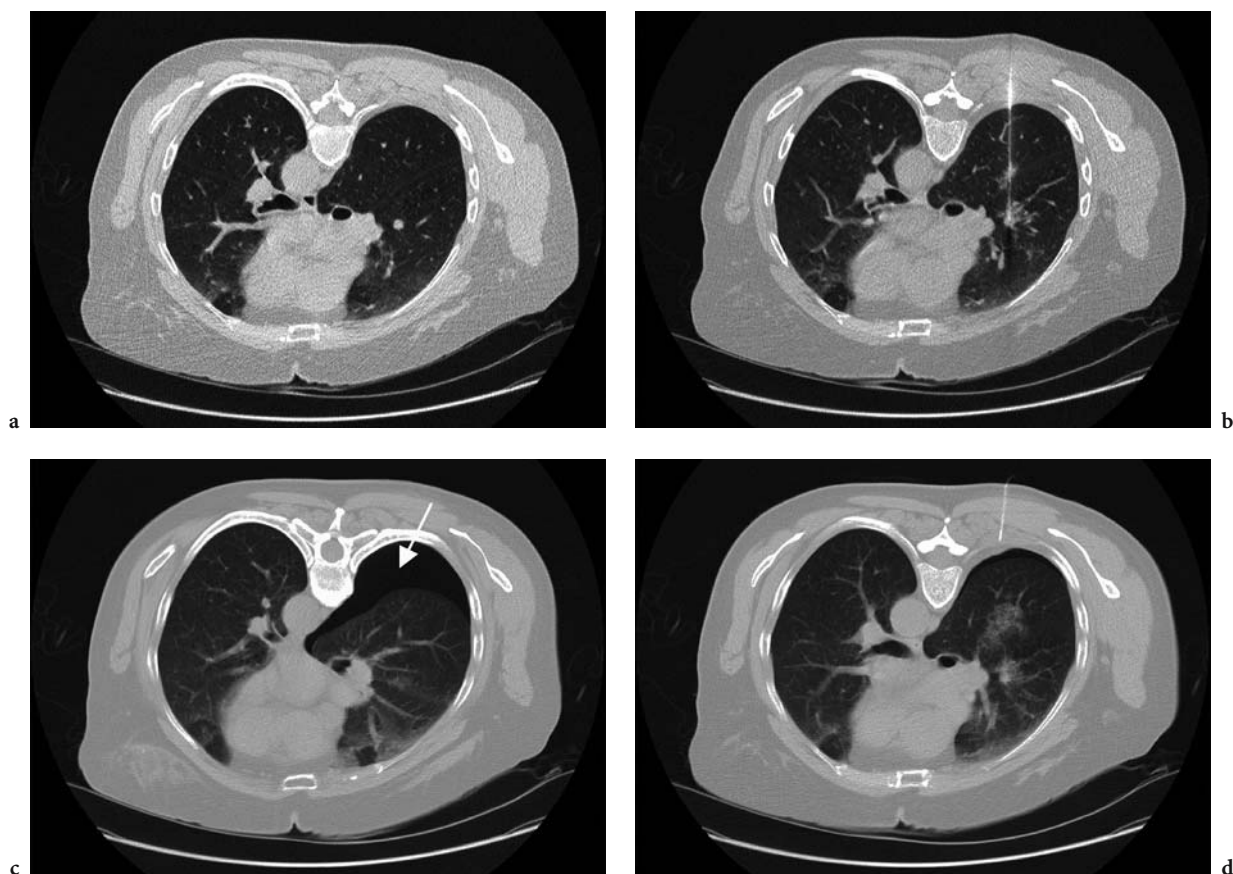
a A small right upper lobe nodule with patient in the prone position. It was felt that even though the needle would pass through the fissure, thus increasing the possibility of pneumothorax (PTX), that the likelihood of success would be improved using this approach. b Needle tip is seen within the nodule. c Several minutes post procedure, a post biopsy CT image shows a moderate size PTX (arrow). d Following aspiration of the PTX using a small catheter (a portion of the catheter is seen in the soft tissue) the PTX is almost completely resolved. On follow-up CXR several hours later, only a minimal PTX could be identified, and the patient was subsequently discharged
